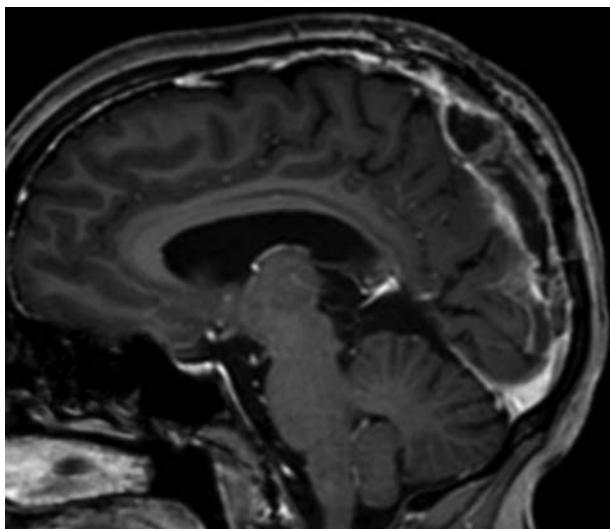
Sagittal T1-weighted magnetic resonance imaging with contrast showing tumor recurrence located within the superior sagittal sinus in the middle and posterior third.
